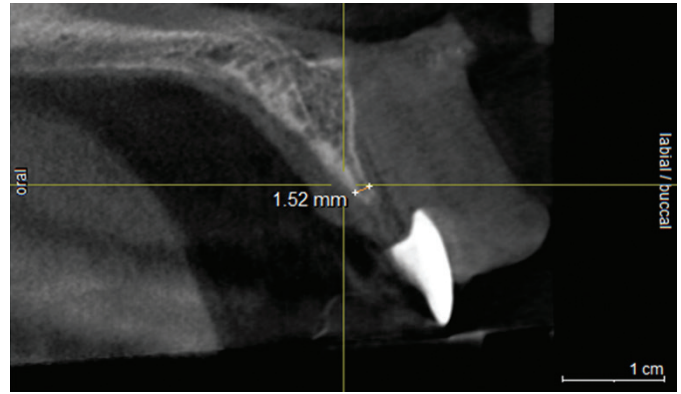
CBCT image showing deficient crestal bone width.
